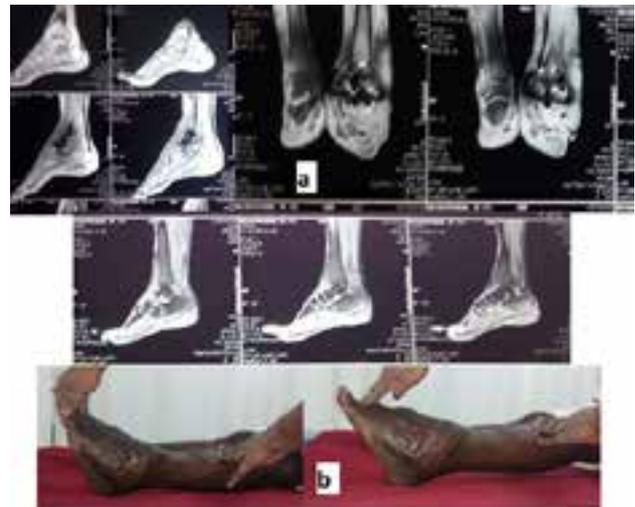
a) MRI showing revascularisation, b) range of movement at 2 year follow up
